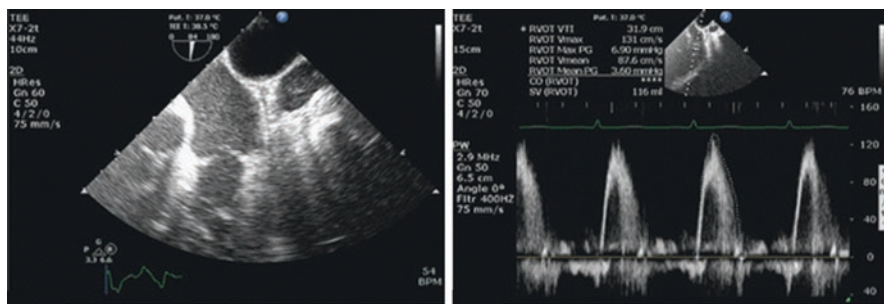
TEE assessment of delta VTI % or delta Vpeak % can also be done using the upper esophageal aortic short axis view so that the pulsed wave Doppler signal is parallel to the right ventricle outflow tract
